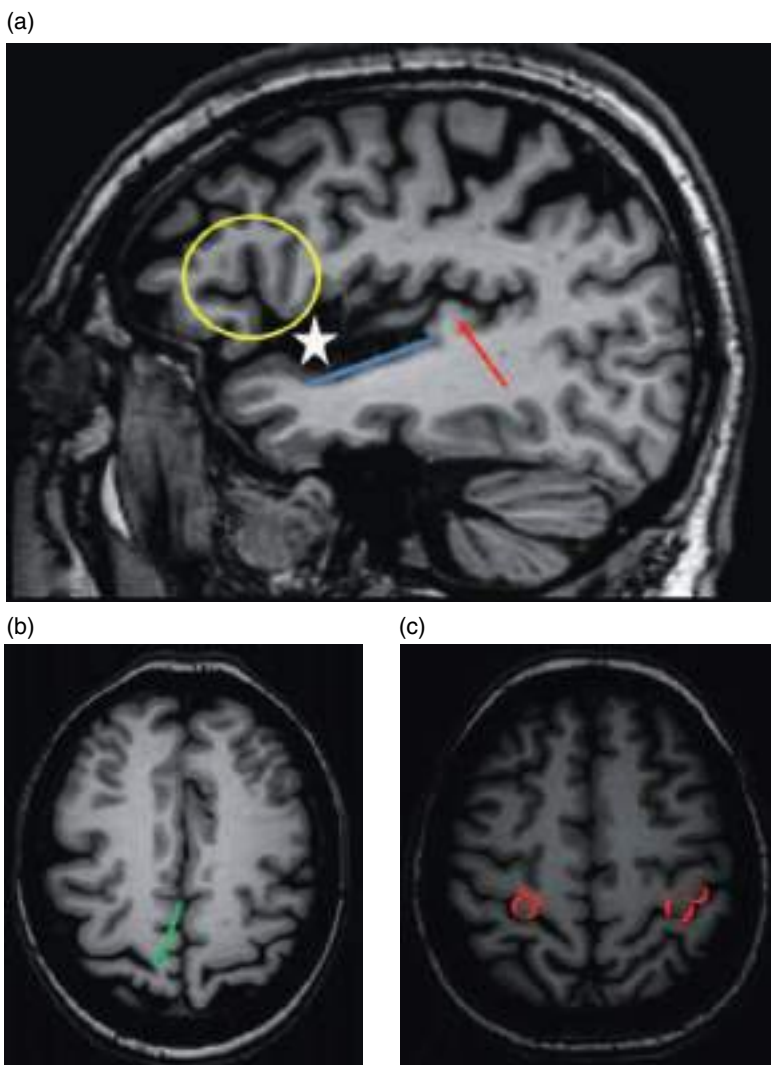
Landmarks of cortical anatomy. (a) Sagittal T1-weighted MRI. (b, c) Axial T1-weighted MRI with different angulation. (a) The Sylvian fissure (white asterisk), the superior face of the temporal lobe with the planum temporale (blue line), and the Heschl's gyrus (red arrow). The opercular region (yellow circle) lies above the Sylvian fissure. (b) How the central sulcus does not normally reach the interhemispheric fissure (green arrow). (c) Typical appearances of the motor area of the hand at the central gyrus, i.e. inverted omega shape on the right side and epsilon shape on the left side.
